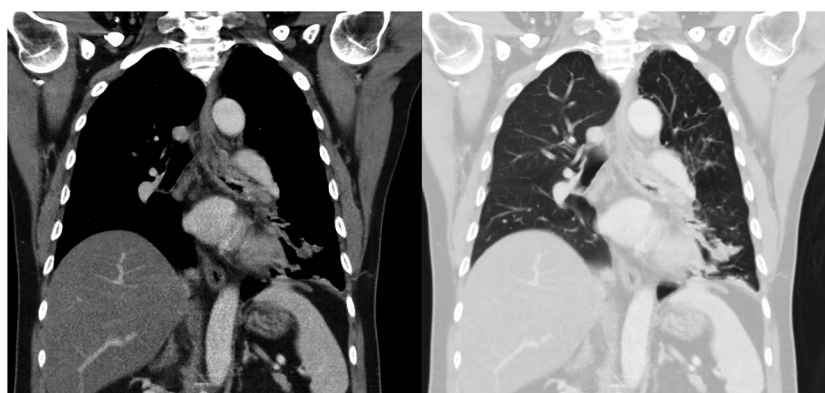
CT Thorax showing left main bronchus narrowing and left lower lobe bronchiectasis.
